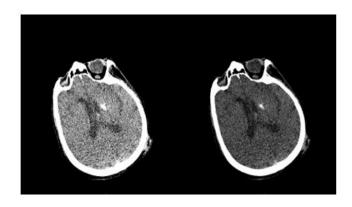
CT scan images of the brain at 80 KV with window settings for parenchyma (left) and angiography (right).
